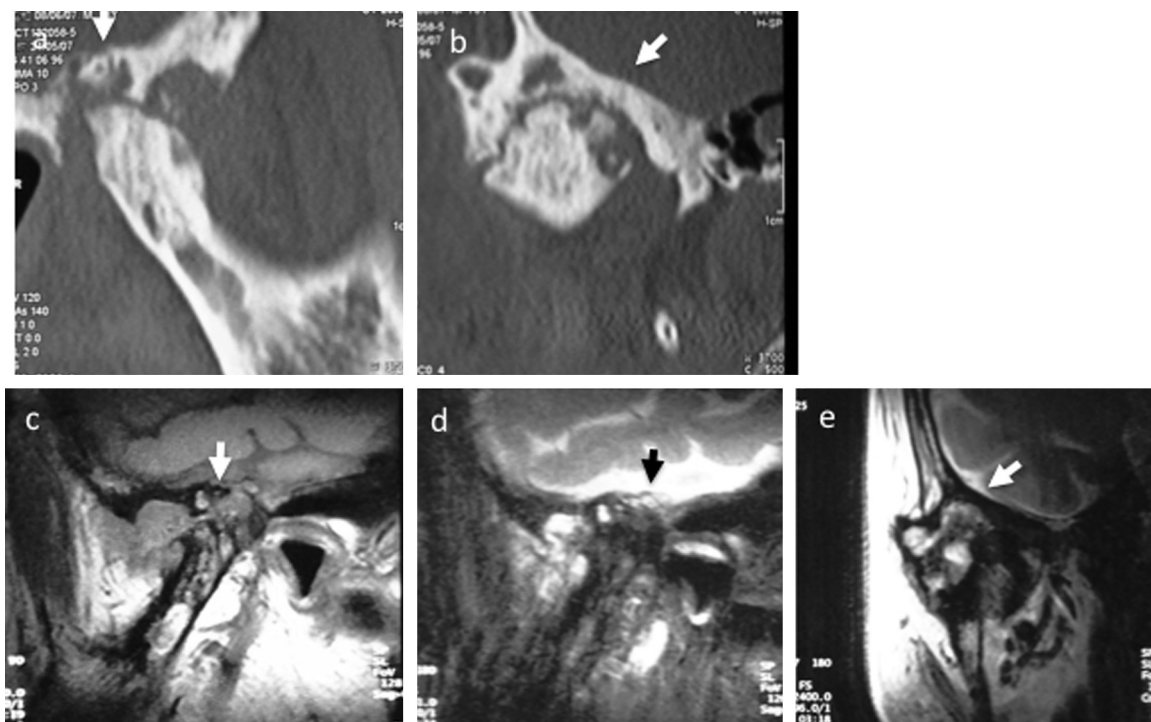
(a,b) CT at 7 years after surgery (a,b). The bone defect of the glenoid fossa had decreased compared with CT at 6 months after surgery ((a,c) sagittal plane, (b,d) frontal plane). (c–e) MRI at 7 years after surgery ((a) sagittal plane on PdWI, (b) sagittal plane on T2WI, (c) frontal plane on T2WI). A mixed high and low signal intensity area was observed behind the condyle on T2WI (arrows).
